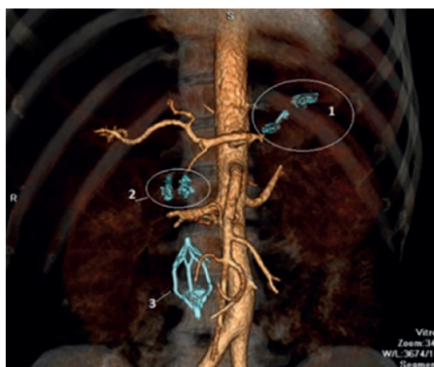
Computed tomography and angiography. 3D reconstruction: condition after embolization of the splenic artery (1), gastroduodenal artery, superior and inferior pancreaticoduodenal arteries (2), installation of a cava filter (3). Data for aneurysm or extravasation not received
